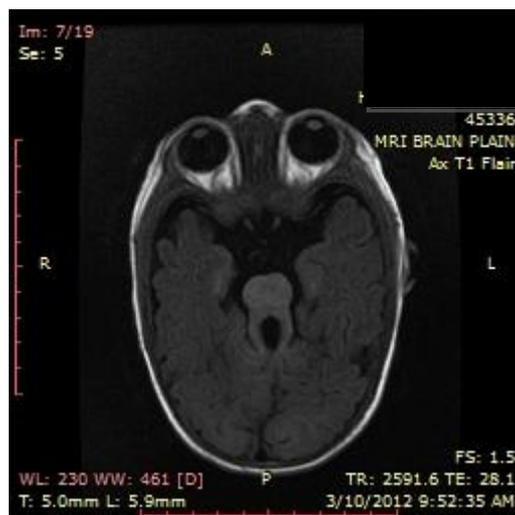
MRI with suggestive findings
